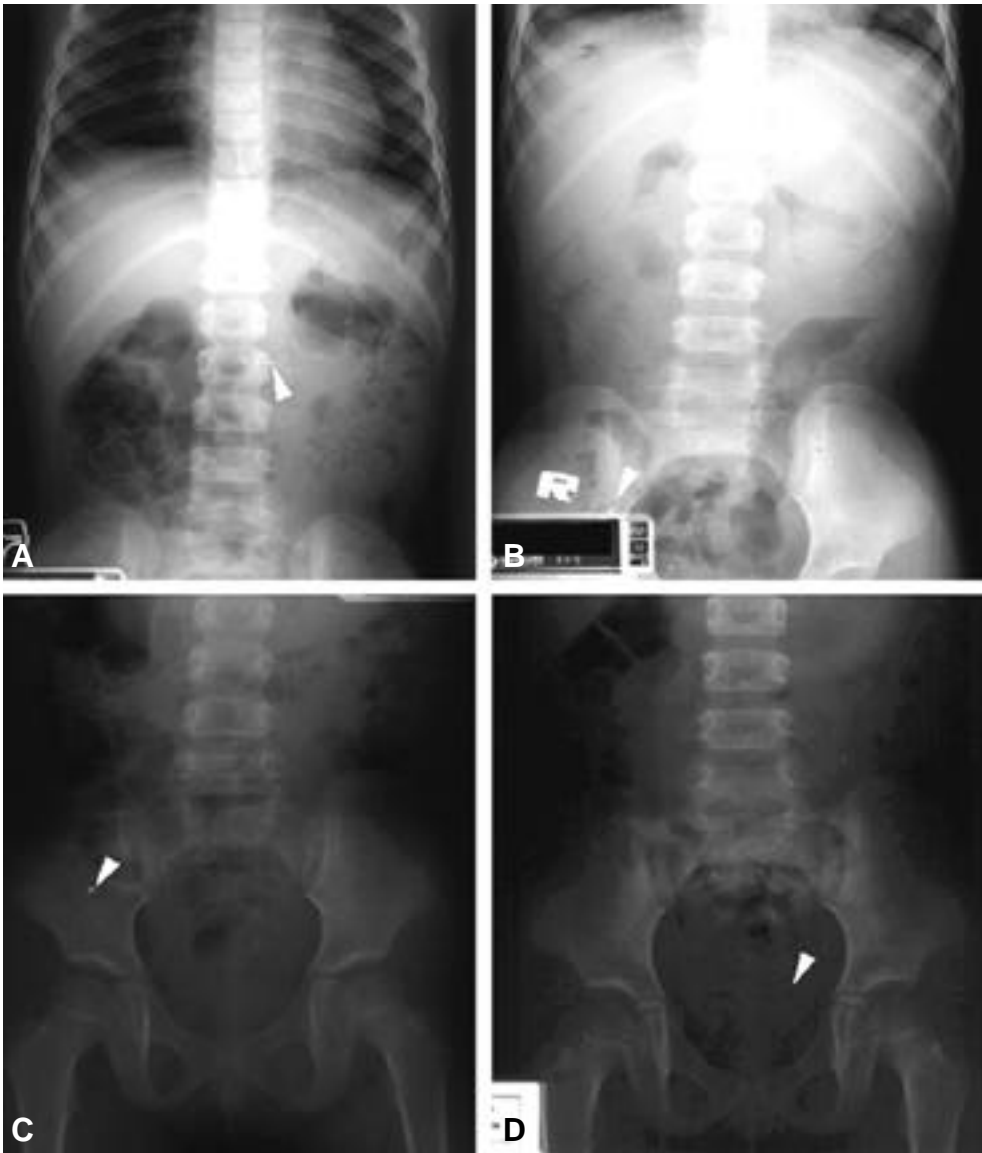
Radiograph series after ingestion. Small particles of mercury (arrowheads) in the stomach(A, 1 day after ingestion), the small intestine(B, 2 days after ingestion), the ileocecal valve(C, 3 days after ingestion) and the rectum(D, 4 days after ingestion)
